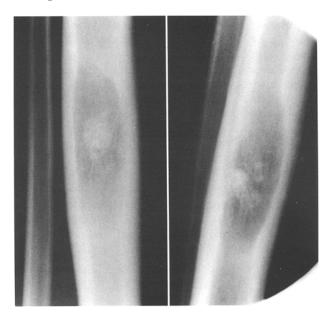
AP (*left*) and lateral radiographs (*right*) show a radiolucent lesion in the midshaft of the tibia with central areas of spotty calcification. The cortex is partly enlarged with scalloping on its inner surface
